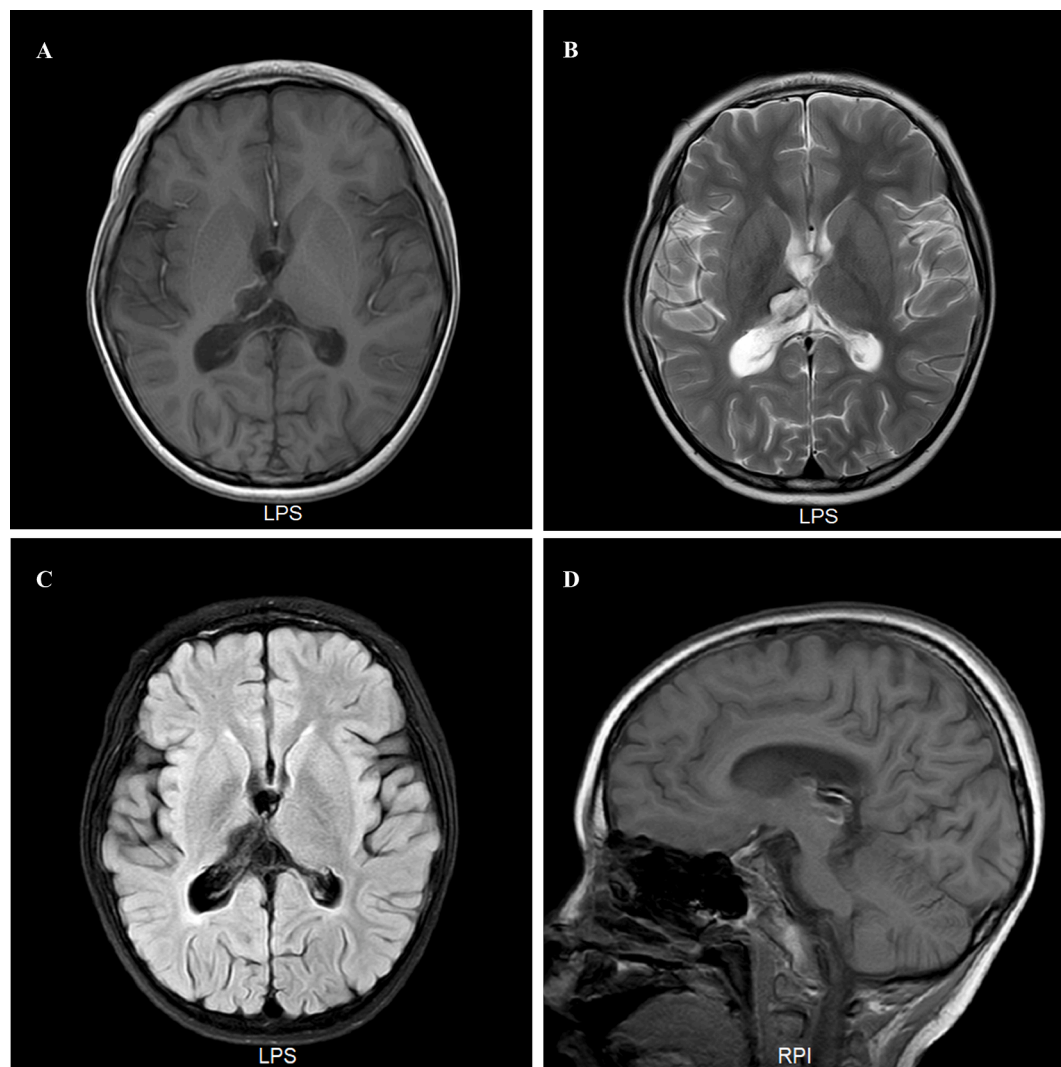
Brain MRI of the patient in March 2020. MRI [(A, D) T1, (B) T2, (C) FLAIR] demonstrated cerebral softening lesions in the right thalamus and posterior and splenium of the corpus callosum.
